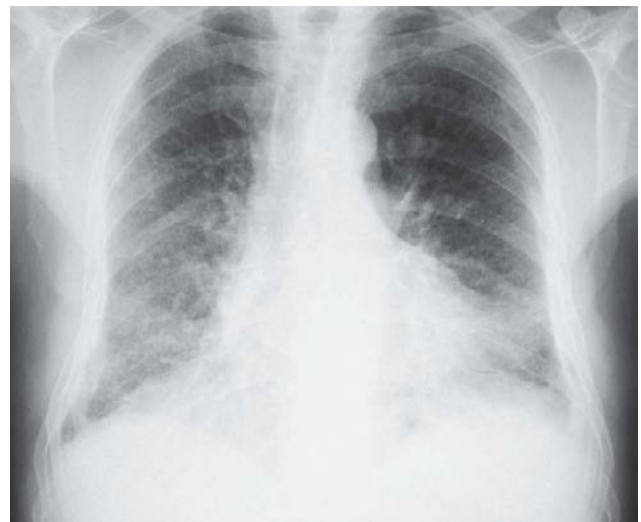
Chest x-ray of a patient diagnosed with combined pulmonary fibrosis and emphysema. A bilateral interstitial pattern can be seen, predominantly right-sided, with reticulonodular infiltrates in the lung bases and subpleural region, and a reduction of lung density in upper lung fields, mainly on the left.
